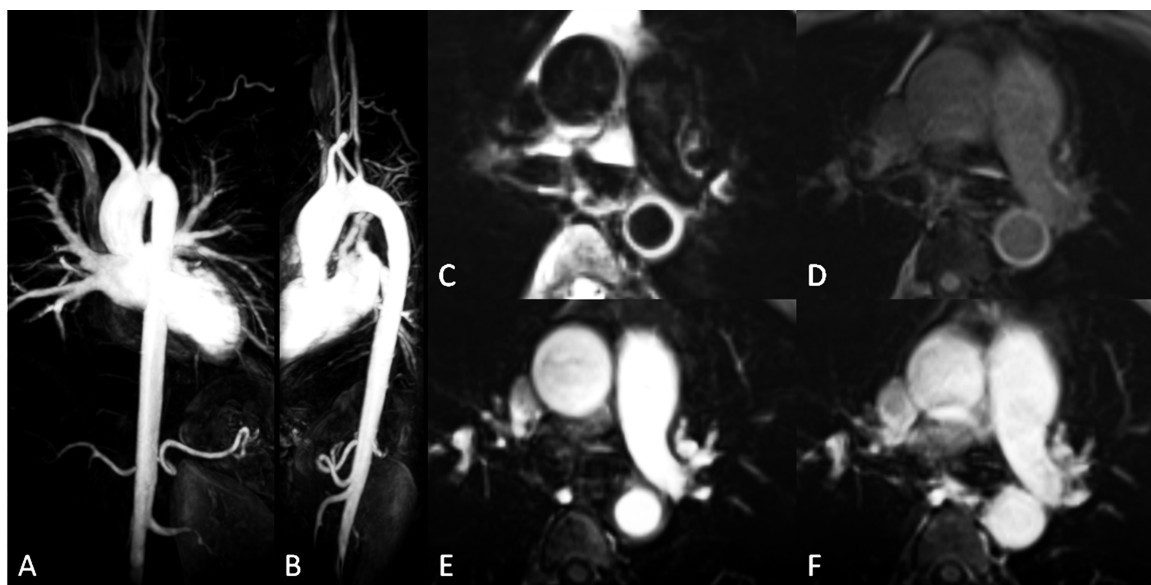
MRI findings of a 32-year-old female patient with active TAK with an ITAS2010 score of 10, an ESR of 14 mm/h, and a CRP level of 32.16 mg/L. (A,B) CE-MRA showed occlusive lesions at the LSCA, RCA, and right renal artery. Significant stenosis was observed at the RSCA. (C) T2WI showed a thickened descending aortic wall with obvious edema. The thickness of the descending aortic wall was 4.65 mm. (D–F) Early and delay enhancement of the thickened descending aortic wall were observed with an early SIR of 2.20, an early ESIR of 5.46, a delay SIR of 2.95, and a delay ESIR of 6.84.
